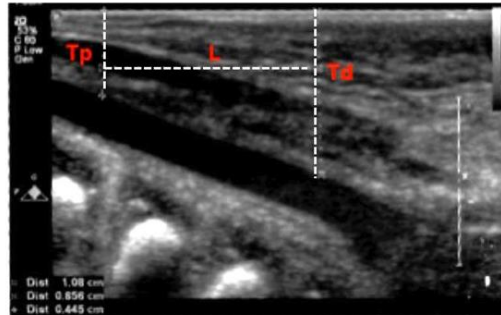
Ultrasound of the right common carotid artery in a preterm human infant, where T_p is the proximal depth of the vessel from the skin surface, T_d is the distal depth from the skin surface and L is the distance between T_p and T_d .
